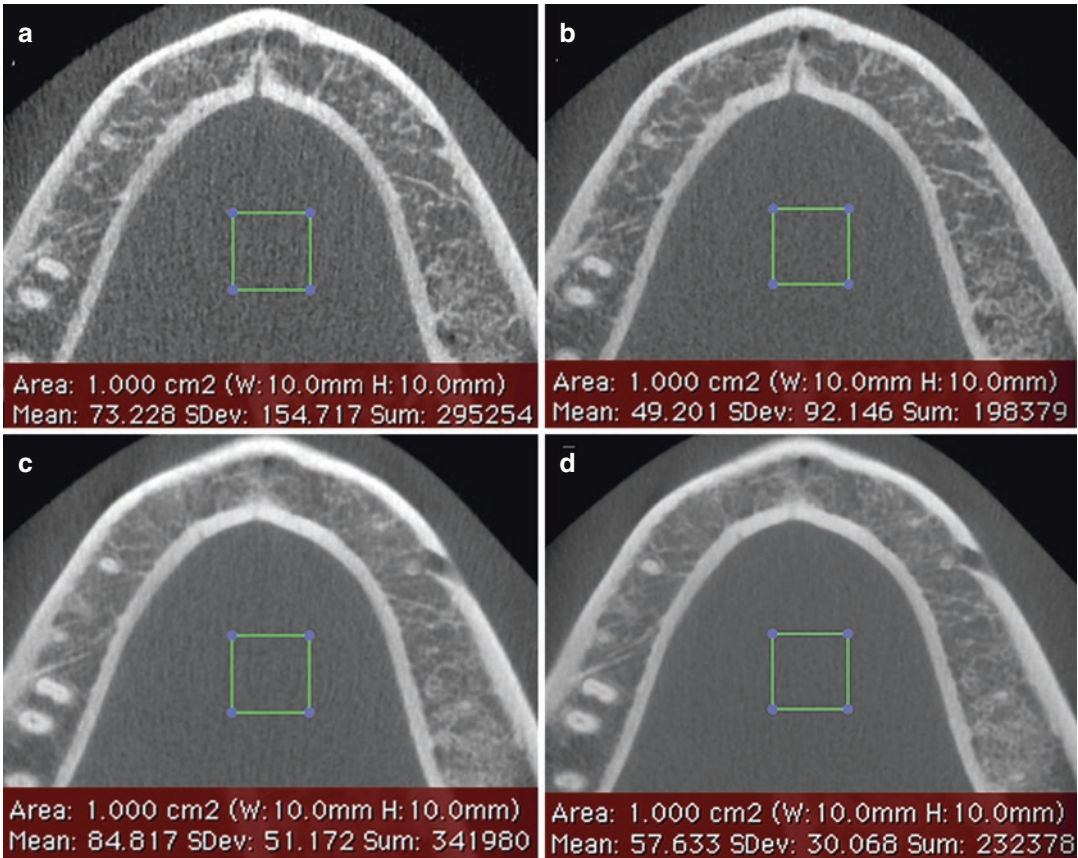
Image noise refers to the local nonuniform density differences in a radiographic image and may affect diagnostic efficiency. In other words, noise includes all those greyscale inhomogeneities in a CBCT image, or any radiographic image for that
